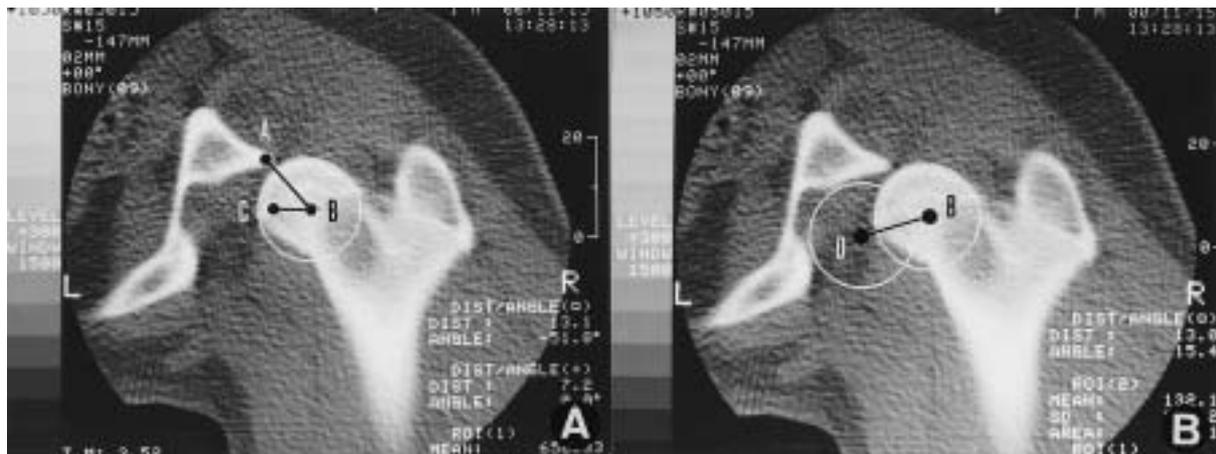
Measurements of the parameters reflecting hip joint congruity. A: Measurement of the lateral center edge angle (LCEA). The LCEA was defined as the angle determined by the dorsal edge of the acetabulum (A), the center of the femoral head (B), and horizontal line (B-C) on a CT image. B: Measurement of the center distance (CD). The CD was defined as the distance between the center of the femoral head (B) and that of the acetabulum (D) on a CT image.
